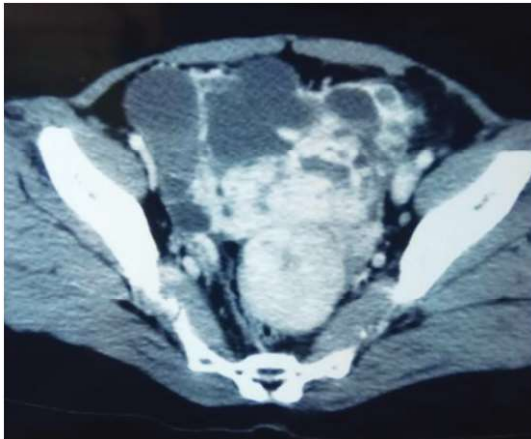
CT image of myoma
